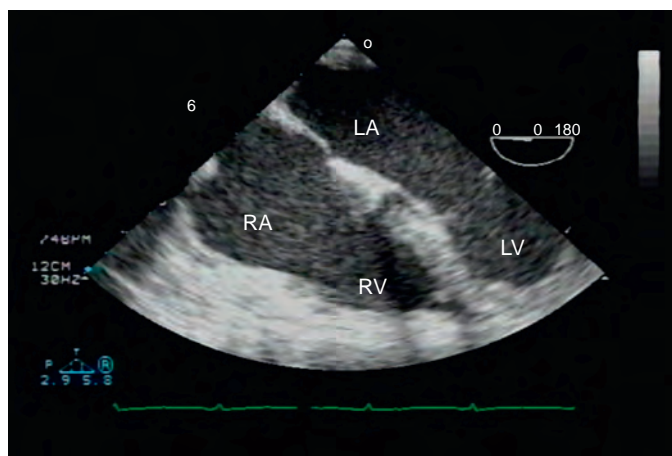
Midesophageal four-chamber transesophageal echocardiographic view after excision of the remaining portion of the mediastinal tumor. LA, Left atrium; LV, left ventricle; RA, right atrium; RV, right ventricle.
